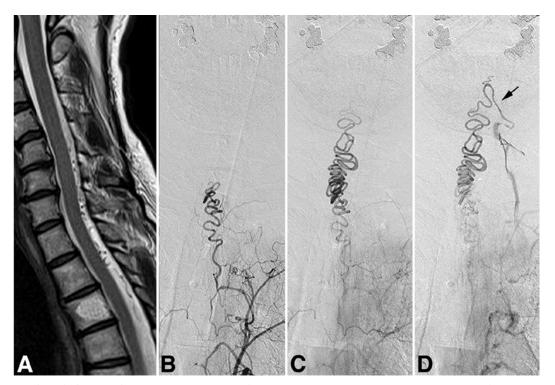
Case 9. Sagittal T2-weighted MR image (A) of the cervicothoracic spine demonstrating abnormal flow void signals in the dorsal subarachnoid space from the C-5 to the T-3 level. There is no abnormal signal in the spinal cord. Anteroposterior angiograms of the left T3–4 segmental artery demonstrating a shunt fed by the T-3 radiculomeningeal artery (B), draining via a radicular vein into ascending perimedullary veins (C), which opened to the external paravertebral plexus via the left C-2 radicular vein (D, arrow).
